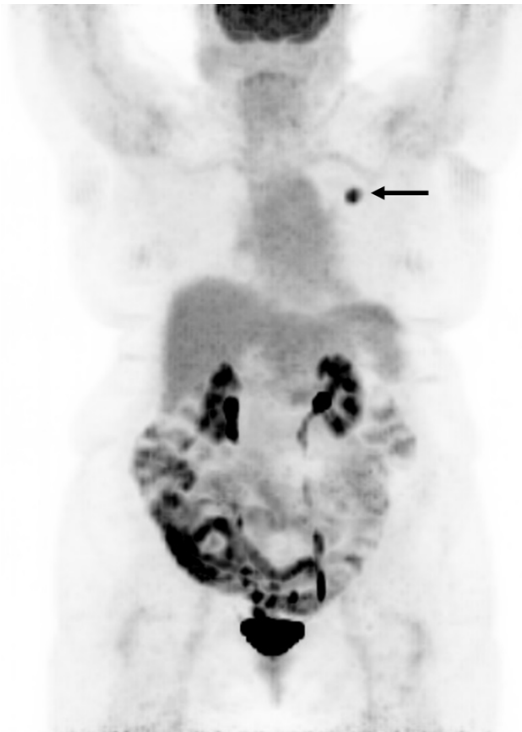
FDG PET projection image in a representative patient with left upper lobe lung adenocarcinoma (arrow), BGL = 166 mg/dL, $SUV_{max} = 6.3$ and $SUV_{gluc} = 10.5$.
